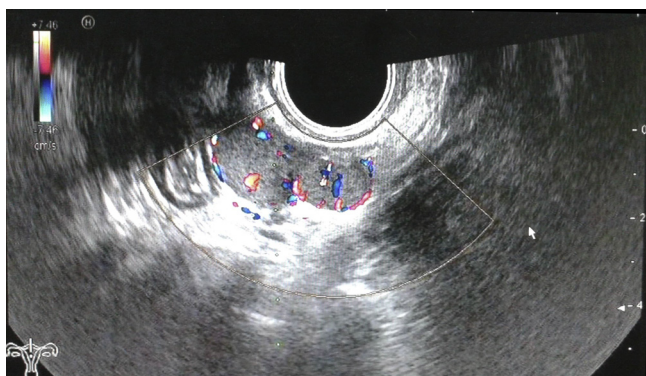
Power doppler image demonstrating rich vascularization of the pelvic masses.
